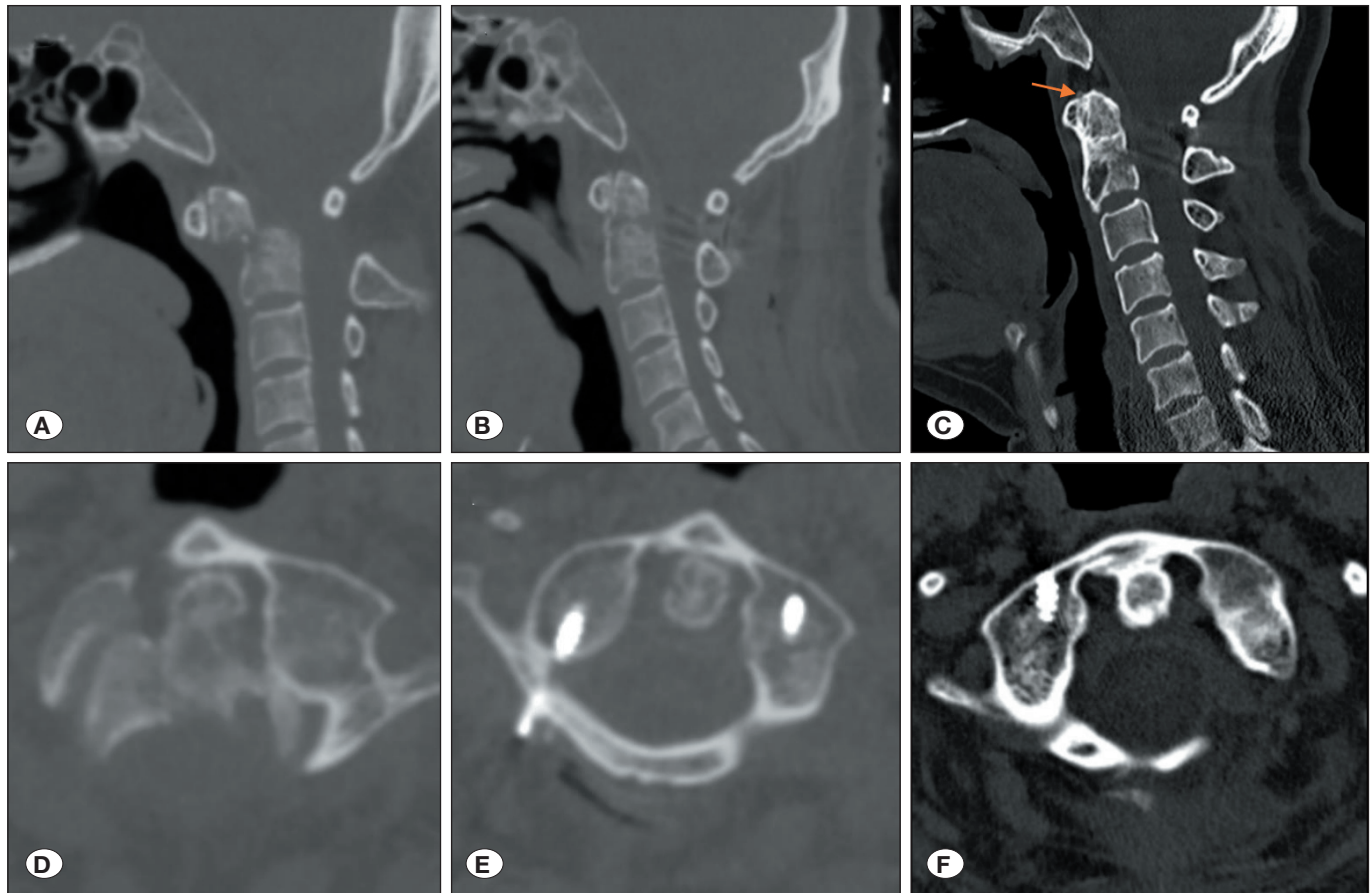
Radiologic evaluations following posterior C1–C2 fixation for Anderson–D’Alonzo type II odontoid fracture. A 55-year-old male underwent reduction and fixation. A, D Preoperative sagittal and axial computed tomography (CT) scans. B, E Postoperative day 1 CT demonstrating reduction and construct positioning. C, F One-year follow-up CT demonstrating maintained alignment and solid fusion. Arrow indicates fusion between the C1 anterior arch and C2 dens.
